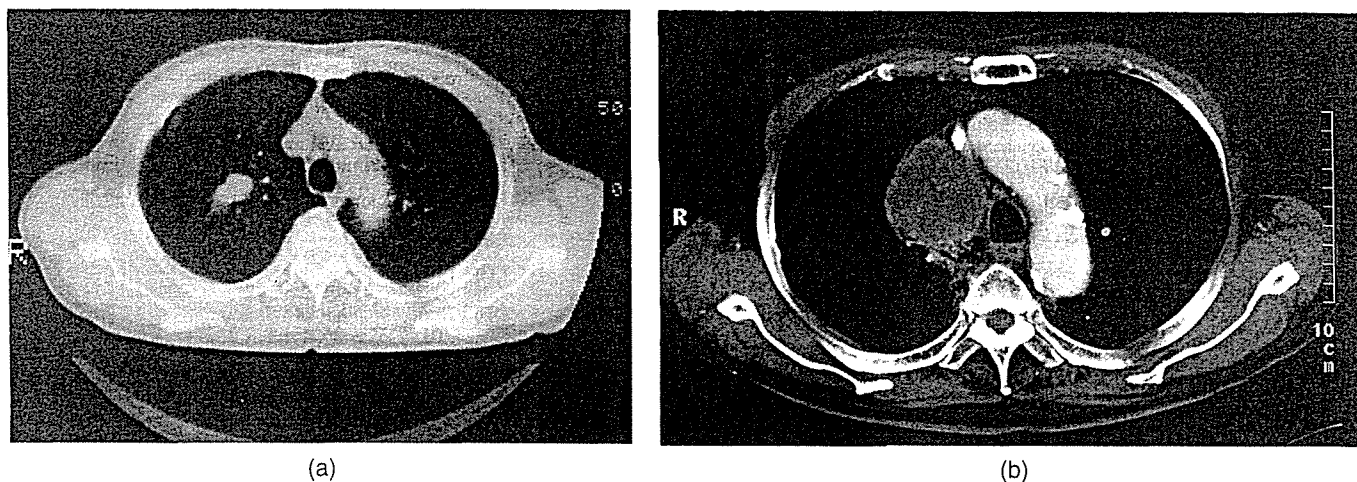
Findings on Chest CT (a) in Case 2 at diagnosis in April 1987. A mass measuring 31 × 13 mm in size in the right upper lobe. Chest CT (b) findings at relapse in 1998.
